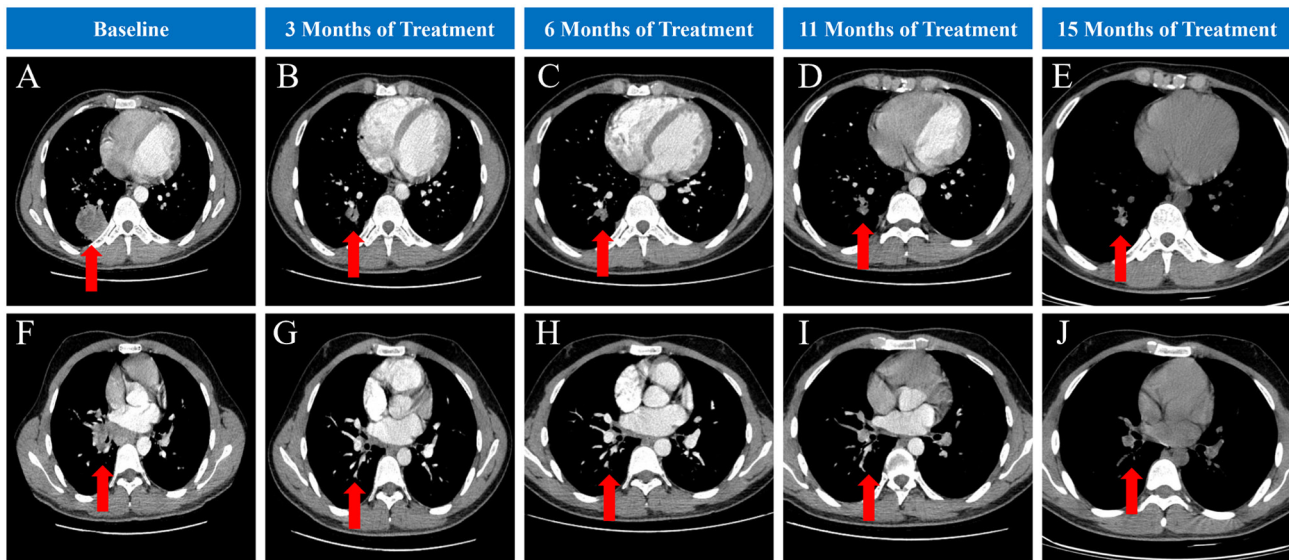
Dynamic monitoring via CT of the patient's response to alectinib. (A) CT shows a large mass in the right lower lobe of the lung at baseline. CT shows partial response after (B) 3, (C) 6, (D) 11 and (E) 15 months of alectinib treatment. (F) CT shows an enlarged right hilar lymph node. CT shows a significant reduction in tumour size after (G) 3, (H) 6, (I) 11 and (J) 15 months of alectinib treatment. CT, computed tomography.
